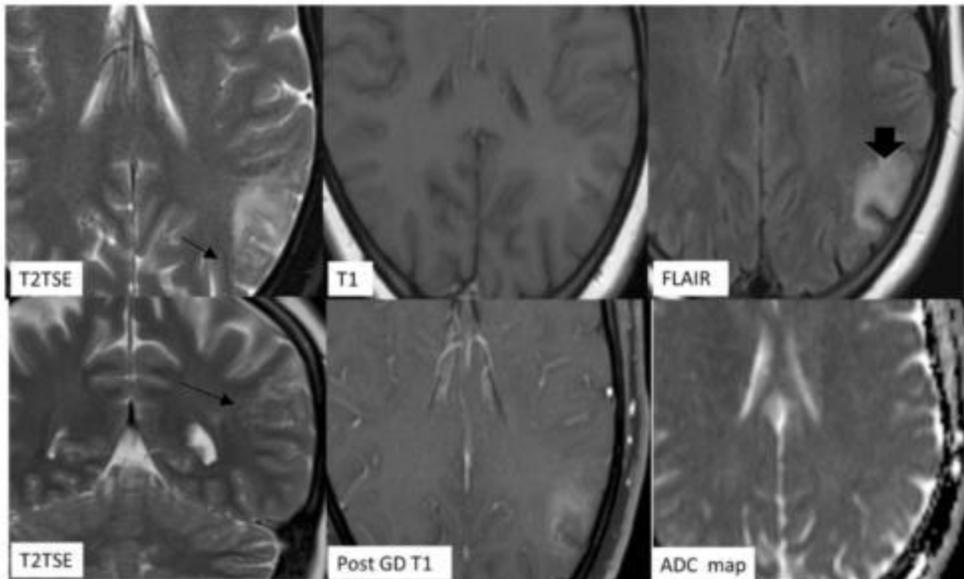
Conventional MRI revealed a left juxtacortical parietal lesion, with partial involvement of the adjacent cortex. Close scrutiny of the periphery of the lesion demonstrated innumerable tiny T2 hyperintense punctate foci clustered together which were confluent centrally (arrow head) but appeared slightly more dispersed peripherally (arrows). These are hyperintense on T2 and FLAIR and hypointense on T1 sequences, with increased diffusivity and minimal enhancement.
